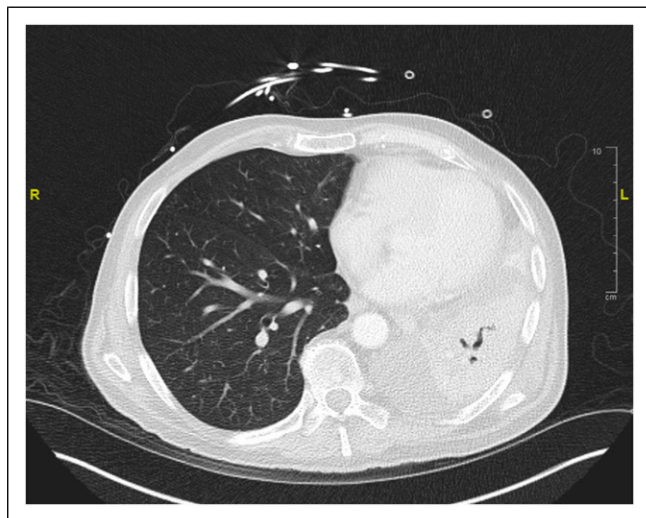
Computed tomography of the thorax demonstrating significant obstruction in the left upper lobe and left lower lobes of the left lung in case 2.
